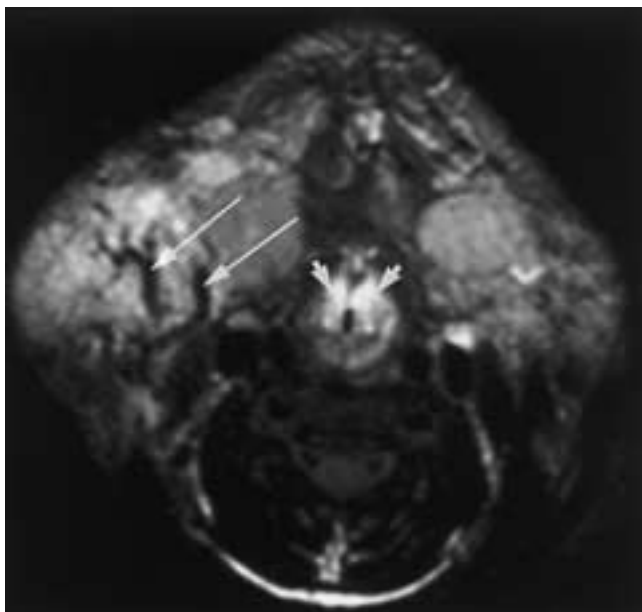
Subglottic and facial hemangioma in a 6-month-old girl. Axial FSE T2-weighted MR image with fat suppression reveals high signal intensity due to hemangioma (*short arrows*) surrounding and narrowing the airway. There is a large, lobulated right submandibular and facial hemangioma. Note the conspicuous flow voids (*long arrows*). The patient had a tracheostomy tube in place and received treatment with alpha interferon.
